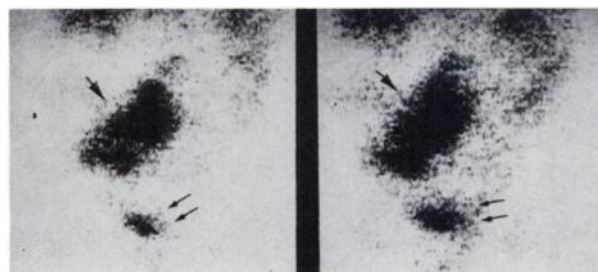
Early (6-hr, left) and delayed (24-hr, right) anterior ^{67}Ga scintigraphs showing abdominal abscess secondary to anastomotic suture leak. Abscess does appear slightly larger on delayed study. Note residual bladder activity on both 6- and 24-hr scintigraphs (double arrows).
